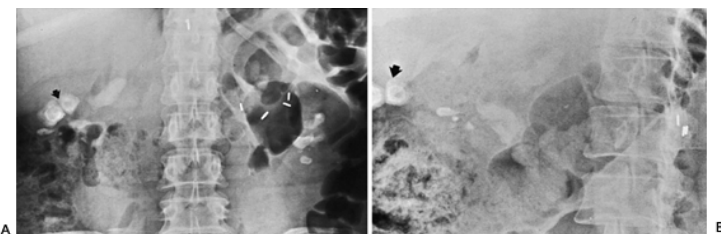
9. A: Preliminary radiograph demonstrates calcific densities overlying both renal shadows. Two laminated calcific densities (arrow) overlying the right renal shadow are probably gallstones. B: Radiograph in the right posterior oblique projection confirms the presence of gallstones (arrow) in addition to renal calculi.
